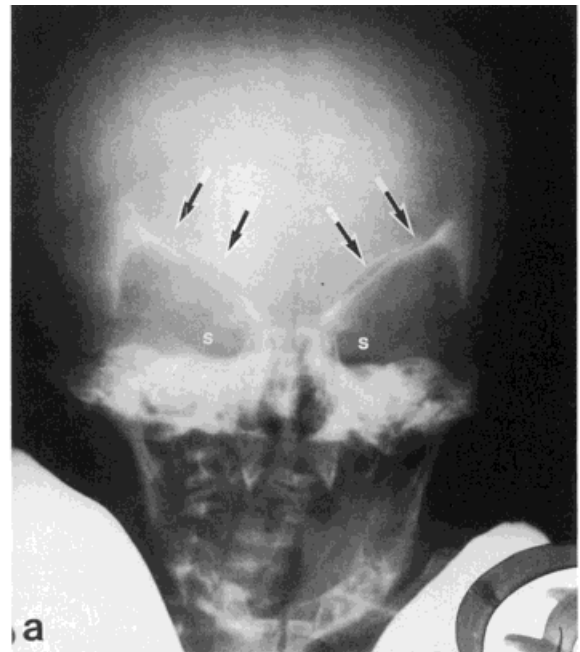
Patient 1, newborn. Frontal (a) and lateral (b) skull radiographs demonstrate shallow orbits with angulation of the orbital roofs (arrows) and vertical posterior orbital walls (curved arrows). The superior orbital fissures(s) are large.
